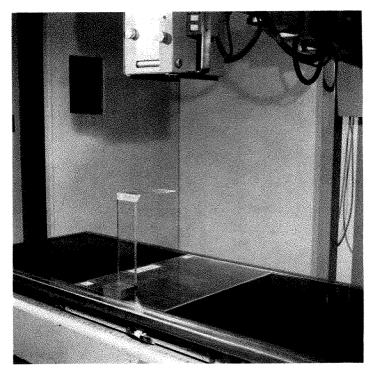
Equipment used to project "fiducial points" onto stereo-roentgenograms.
